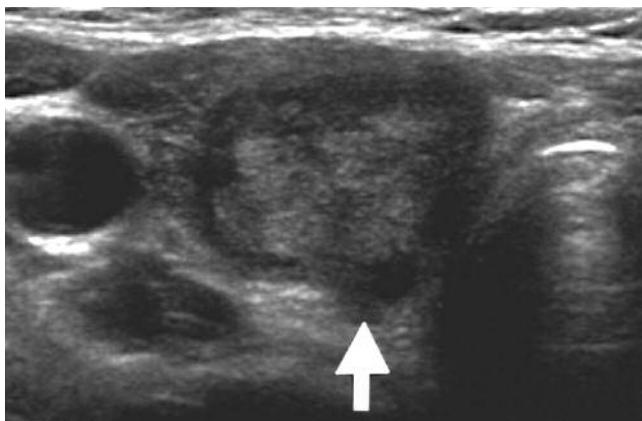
Thyroid ultrasound showing a nodule in the right lobe (arrow) with an irregular border. This nodule requires a FNA biopsy (see Table).
